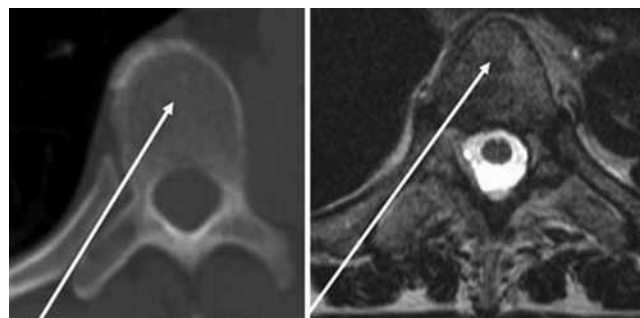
Axial CT scan (A) and axial T2-weighted MR image (B) showing the extrapedicular trajectory (arrow).
